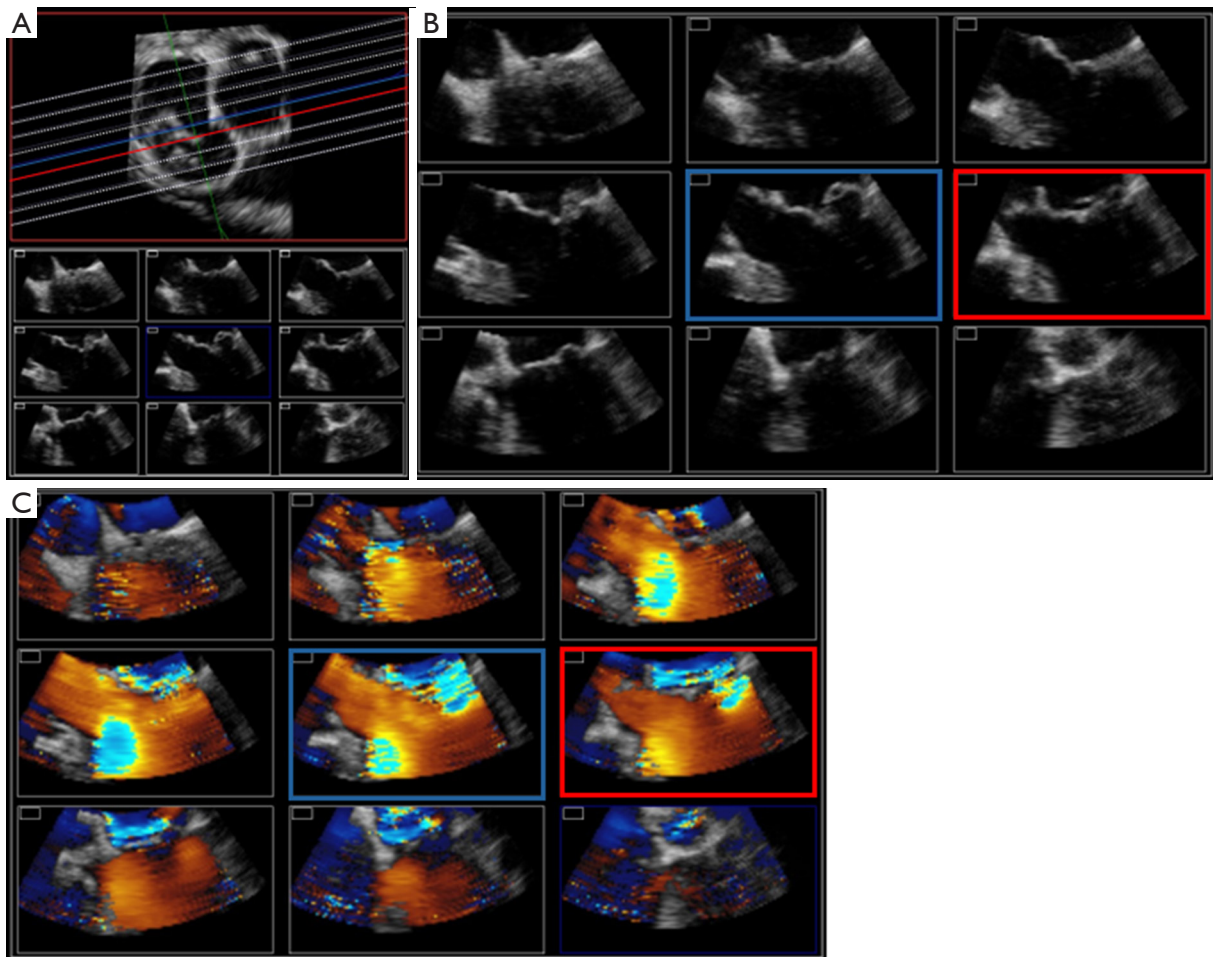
Three-dimensional transesophageal echocardiography volume slicing of the MV. (A) The MV is transected in multiple anteroposterior parallel planes from the lateral to the medial aspect of the mitral valve annulus (white, dotted lines in top image). (B) The tomographic planes are shown simultaneously on display. The blue and red squares show the exact location of the prolapse and flail at the medial aspect of the middle scallop of the posterior mitral leaflet (P3 side of P2). The blue and red squares correspond with the blue and red lines in the top image in (A). (C) Volume slicing with color flow Doppler. The blue and red squares show the exact origin of the jet of mitral regurgitation at the medial aspect of the middle scallop of the posterior mitral leaflet (P3 side of P2). MV, mitral valve.
